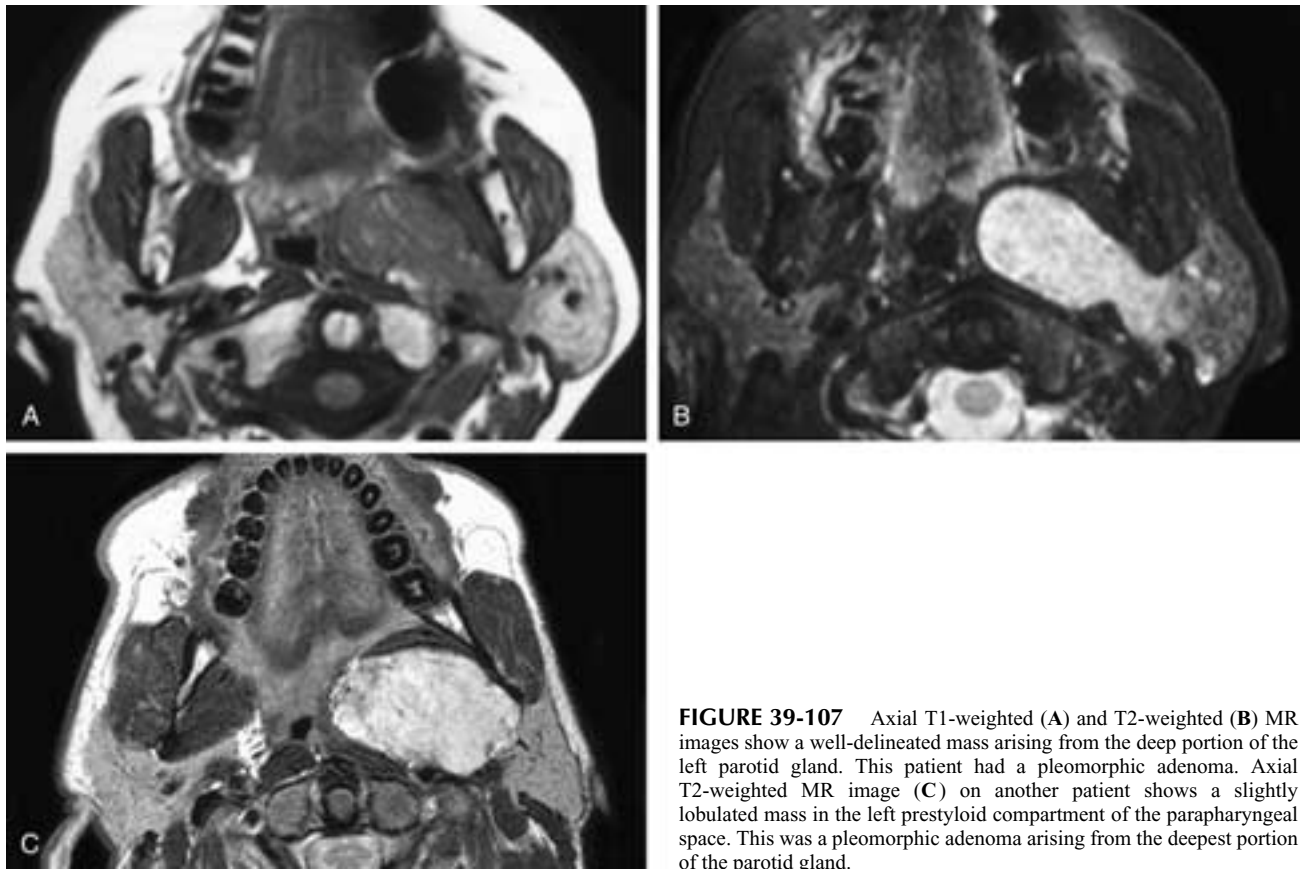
Axial T1-weighted (A) and T2-weighted (B) MR images show a well-delineated mass arising from the deep portion of the left parotid gland. This patient had a pleomorphic adenoma. Axial T2-weighted MR image (C) on another patient shows a slightly lobulated mass in the left prestyloid compartment of the parapharyngeal space. This was a pleomorphic adenoma arising from the deepest portion of the parotid gland.
